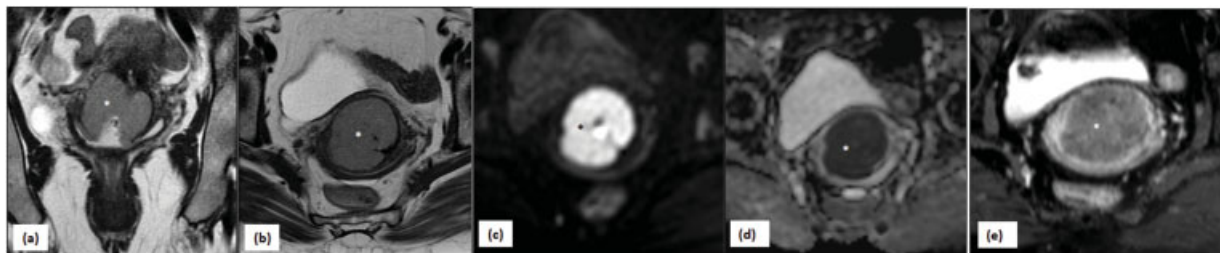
MRI in stage IIA of carcinoma cervix—(a) T2-weighted coronal and (b) axial images show a well-defined hyperintense mass (*asterisk*) involving cervix extending into the fornices. The peripheral hypointense stromal ring is well seen with no parametrial extension. Although the tumor to cervix contrast is well appreciated on T2 WI; the (c) DWI, (d) ADC, and (e) post-contrast sequences delineate the tumor better with confirmation of no parametrial infiltration. ADC, apparent diffusion coefficient; DWI, diffusion-weighted image.
